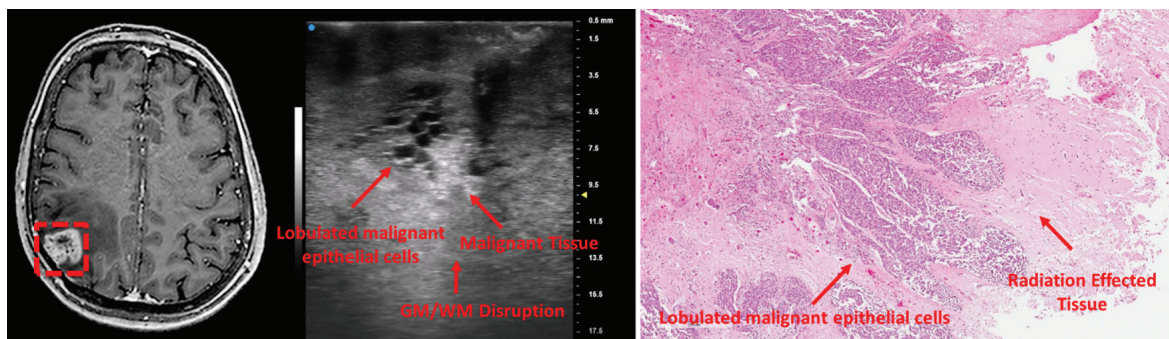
Cranial biopsy tumour resection: MRI, high frequency ultrasound, and pathology comparison shows clearly defined lobular structures characteristic of malignancy.
